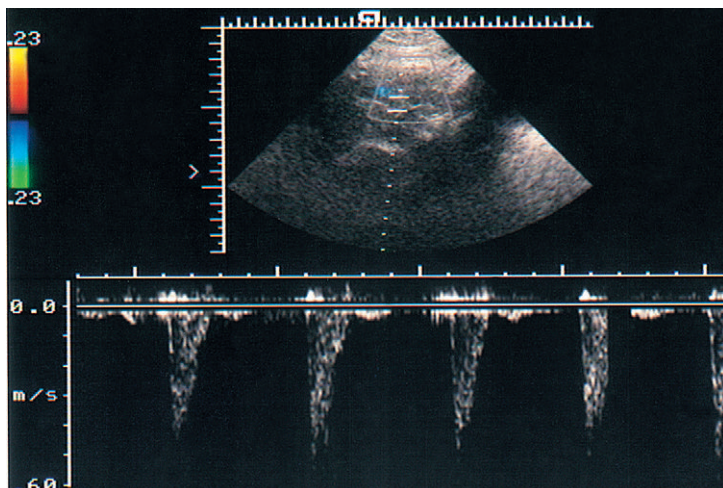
Doppler spectrum of uterine artery blood flow in infertility.
